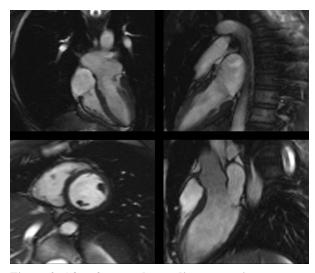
After four weeks cardiac magnetic resonance imaging showed complete lack of ballooning together with an absence of scaring and no abnormalities with regards to wall motion.
